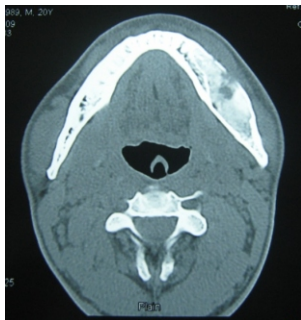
Axial CT showing an expansile lesion
